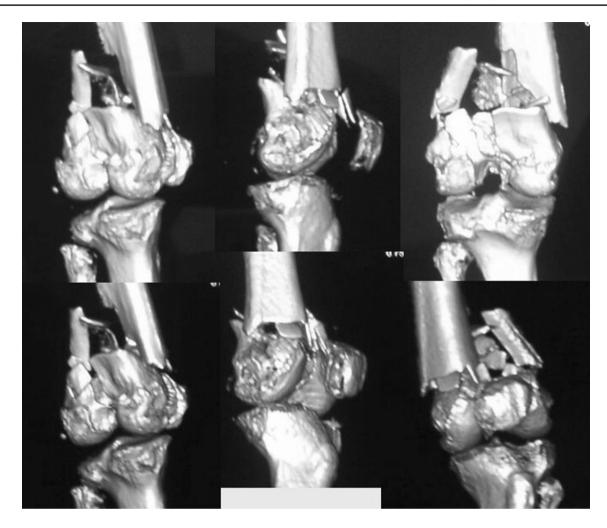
Preoperative CT scan with 3D reconstruction for the same fracture demonstrating better understanding of the fracture geometry
